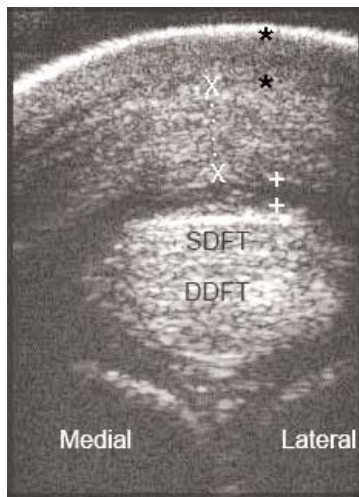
Fig o5: Transverse ultrasonographic view at the level of the plantar aspect of the fetlock region of a 9-year-old pony. The plantar annular ligament (PAL) is severely thickened (X to X, 10.11 mm). There is anechogenic fluid in the digital flexor tendon sheath (+ to +), reflecting effusion. The convex contour on the plantar aspect of the limb gave a fairly narrow window for examination. Assessment of the more abaxial aspects of the PAL required moving the transducer medially and laterally. (Skin * to *). Superficial digital flexor tendon; DDFT = deep digital flexor tendon.
